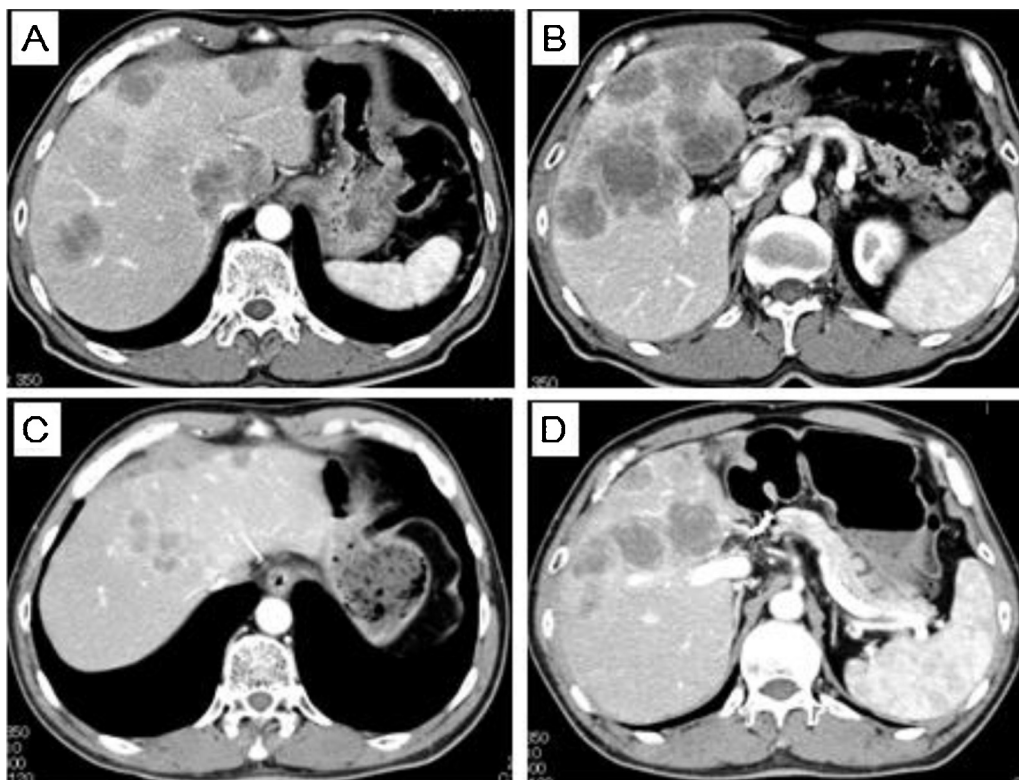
(A, B) Representative images of abdominal computed tomography (CT) prior to treatment. More than 20 metastatic liver tumors were identified, with involvement of the root of the hepatic veins; (C, D) Representative images of abdominal CT after 11 cycles of hepatic arterial infusion chemotherapy. Tumors in the root of the hepatic veins were diminished, and tumors around the porta hepatis were smaller.
